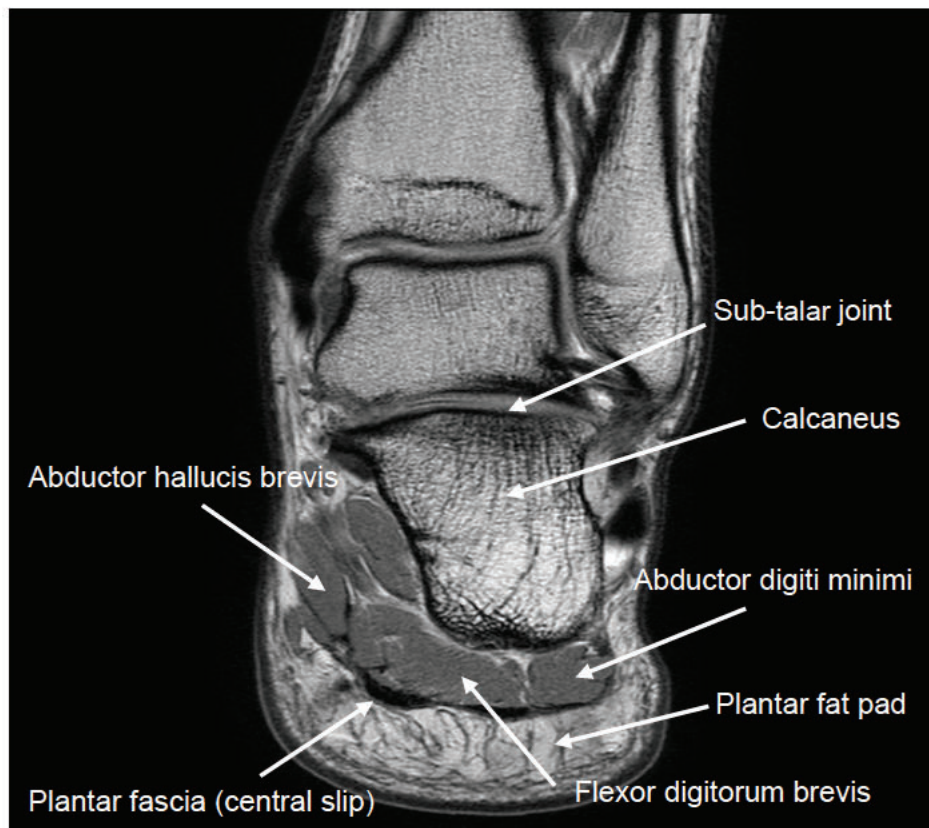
MRI anatomy of the heel and rear-foot
